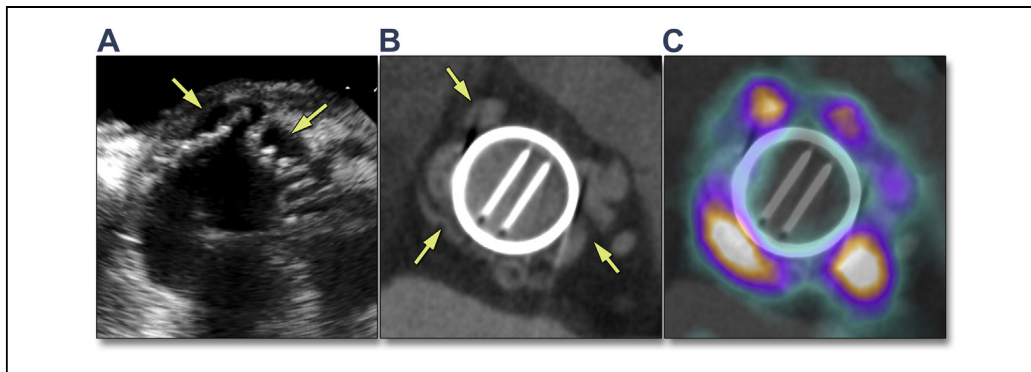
Additional Value of CTA and FDG-PET for the Confirmation of PHV Endocarditis With Periannular Extension
